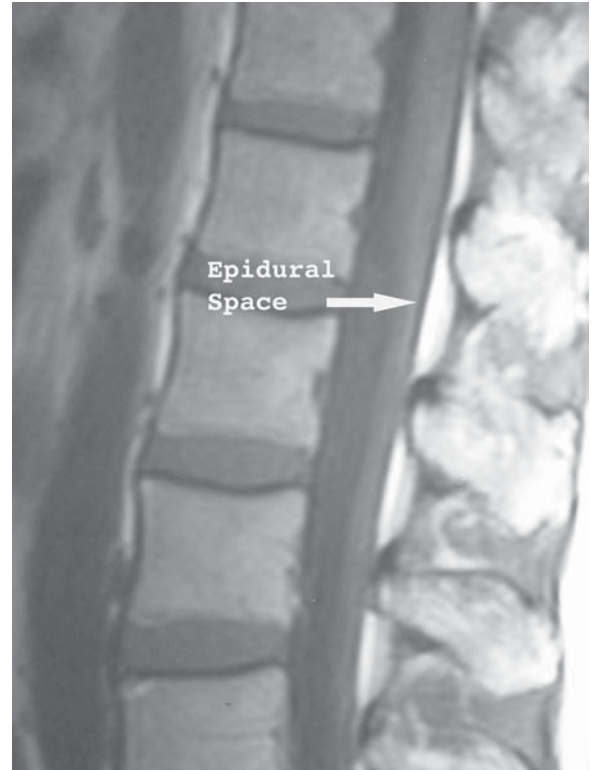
Sagittal MRI of the epidural space. The epidural space is triangular in shape viewed in this sagittal plane, and most prominent in the sublaminar region.
